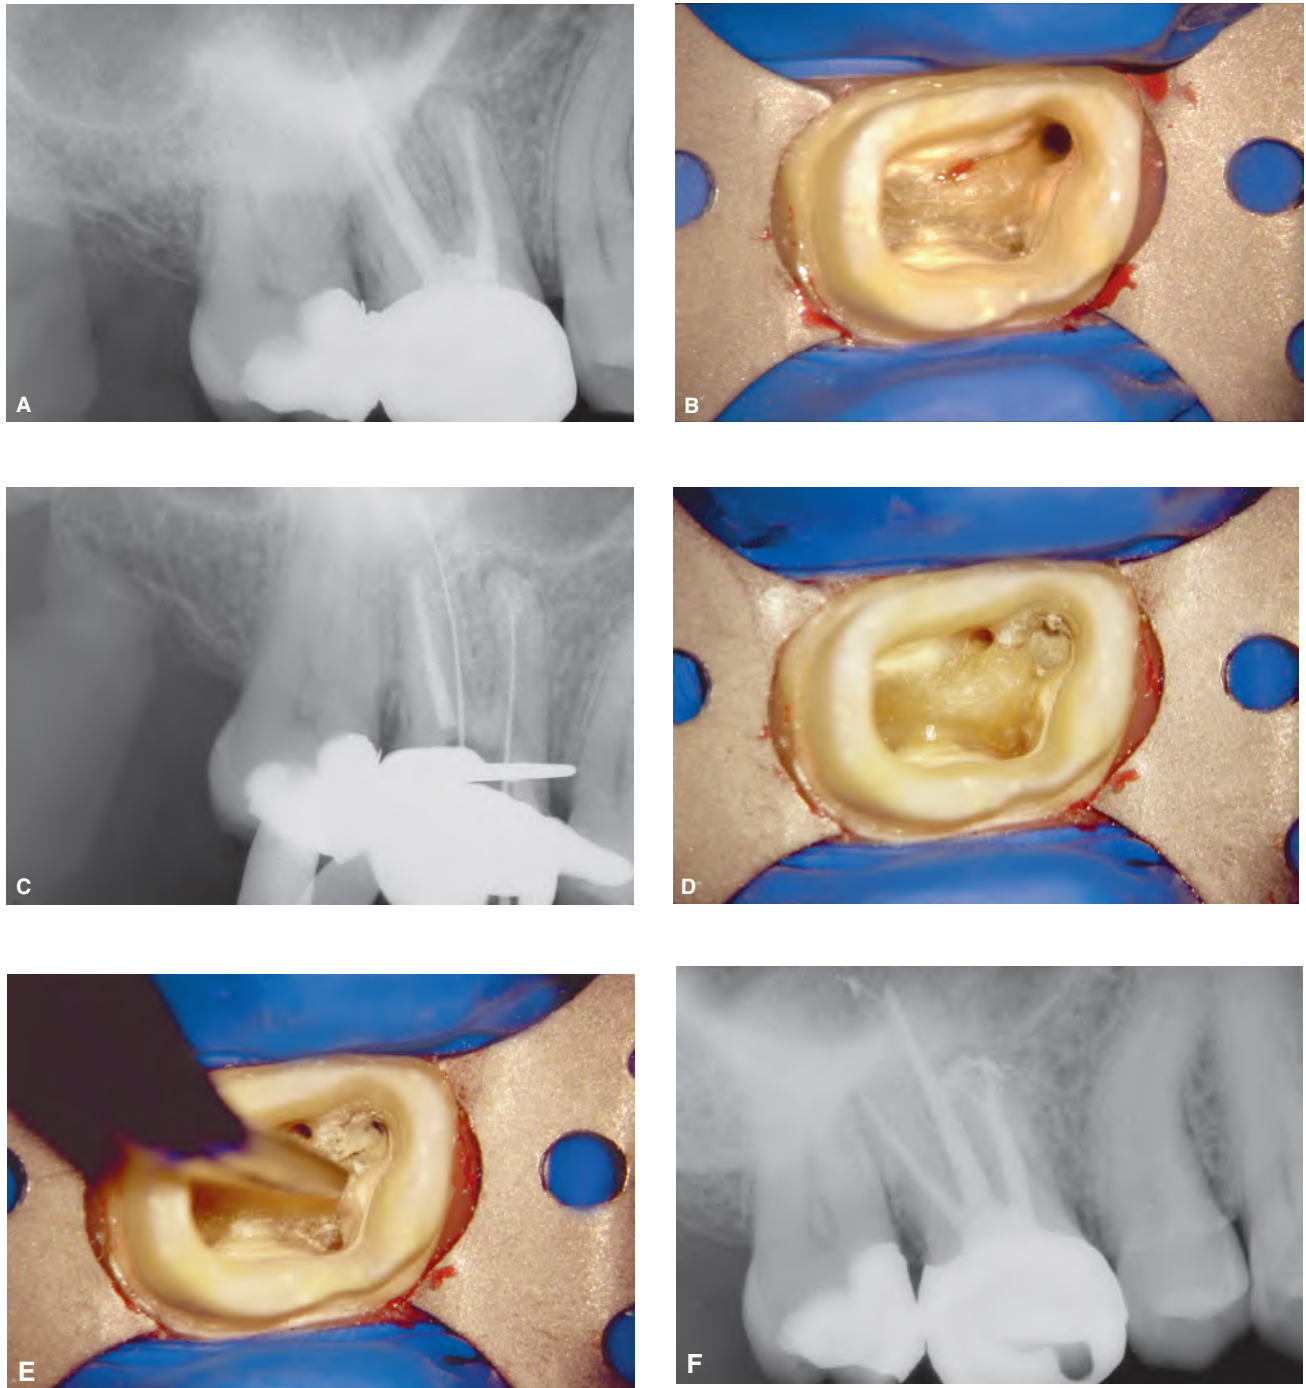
A. Preoperative radiograph of a failing endodontic treatment in a maxillary right first molar. Note the MB root is perforated in its apical one-third. B. Photograph showing crown removal, the MB-1 canal orifice and bleeding emanating from the MB-2 canal system. C. A no. 10 file at the terminus of the MB-2 canal system. D. The prepared MB-2 canal system, a holding file within the MB-1 canal intentionally sectioned below the occlusal surface, and MTA utilized to repair the perforation defect. E. At a subsequent visit, the MTA was brick-hard. At this point the holding file is removed from the MB-1 canal system. F. A Post-treatment radiograph showing the treated MB-1 and MB-2 canal systems, the perforation repair and the block/ledge management of the DB and palatal canal systems.
